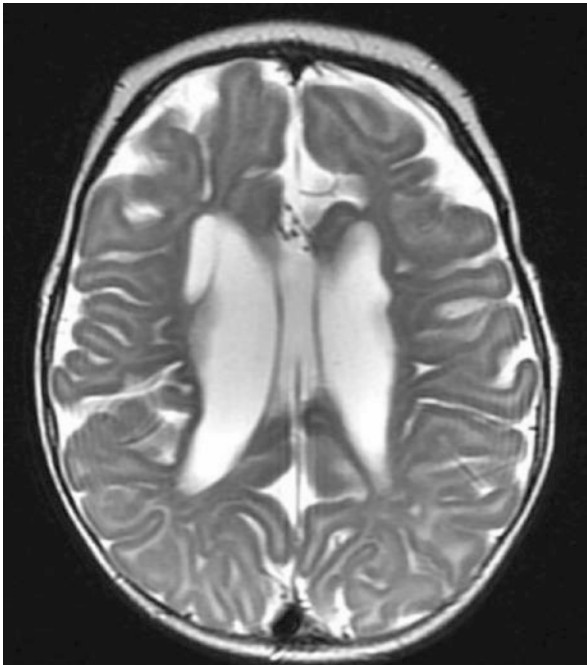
This patient was 5 months of age at the time of MRI scan, T2 image. Note global cerebral volume loss and extensive white matter abnormality. There was a history of maternal diabetic ketoacidosis at 20 weeks of gestation. Head circumference was below 2 SD at time of birth. This patient went on to develop infantile spasms and spastic quadriplegic cerebral palsy
